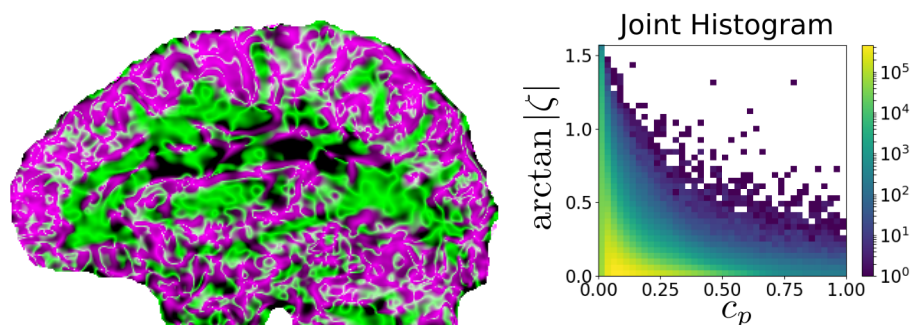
Nonintegrability  $\zeta$  can also be computed from data that has been acquired with a standard clinical DT-MRI protocol. Also in this case, bivariate color mapping and a joint histogram clearly indicate regions of nonintegrability despite high  $c_p$ , shown in black in the sagittal map on the left (please refer to Figure 9.7 for a full legend)
